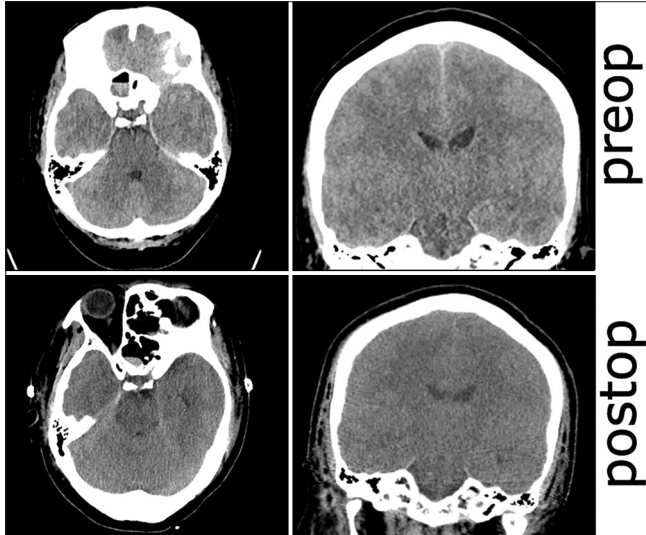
Pre- and post-operative day 1 computed tomography scans. The postoperative scan was acquired shortly after the patient developed a depressed neurologic status and focal neurologic deficit and minutes after mannitol had been started. Postoperative changes, but no focal mass lesions or postoperative complications were seen on the final read. Of note, the brain appears full both pre-and post-operatively.
